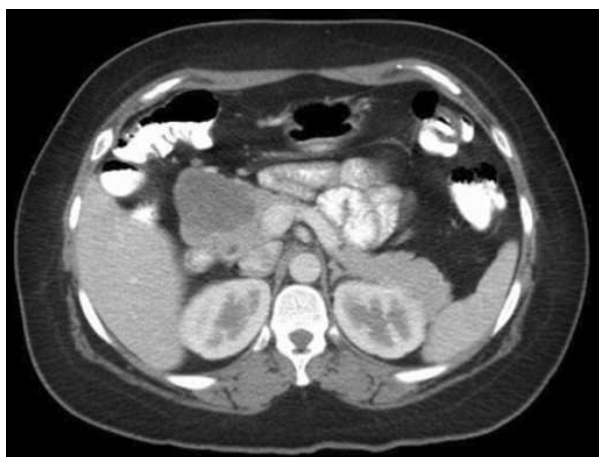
CT scan showing a 5.9x5.6 round cystic mass at the head of the pancreas in a 33-year-old female (Case #1).
